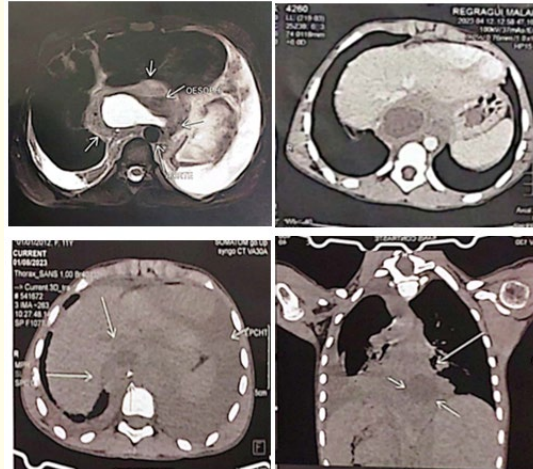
MRI showing a cystic mass in the retro-mediastinum and another in the retroperitoneum extending to the pancreas.
